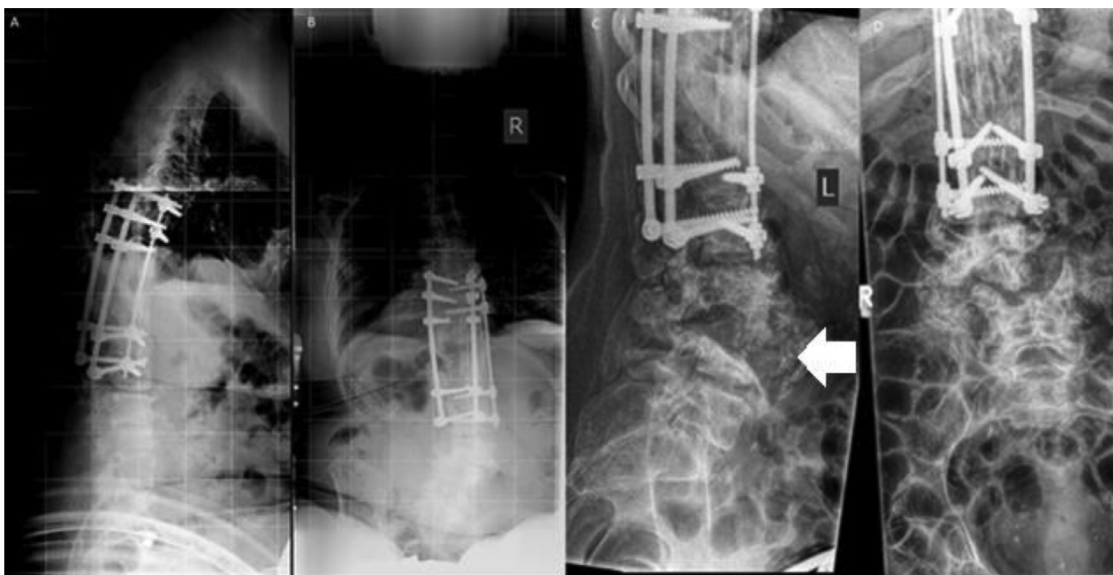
Lateral (A) and frontal (B) radiographs 42 years after the initial trauma in 2011, showing a fused spine at the T8-L2 level with degenerative lumbar scoliosis. The lateral (C) and frontal (D) radiographs 5 years later show new destruction of the L3 and L4 vertebra (white arrow).
